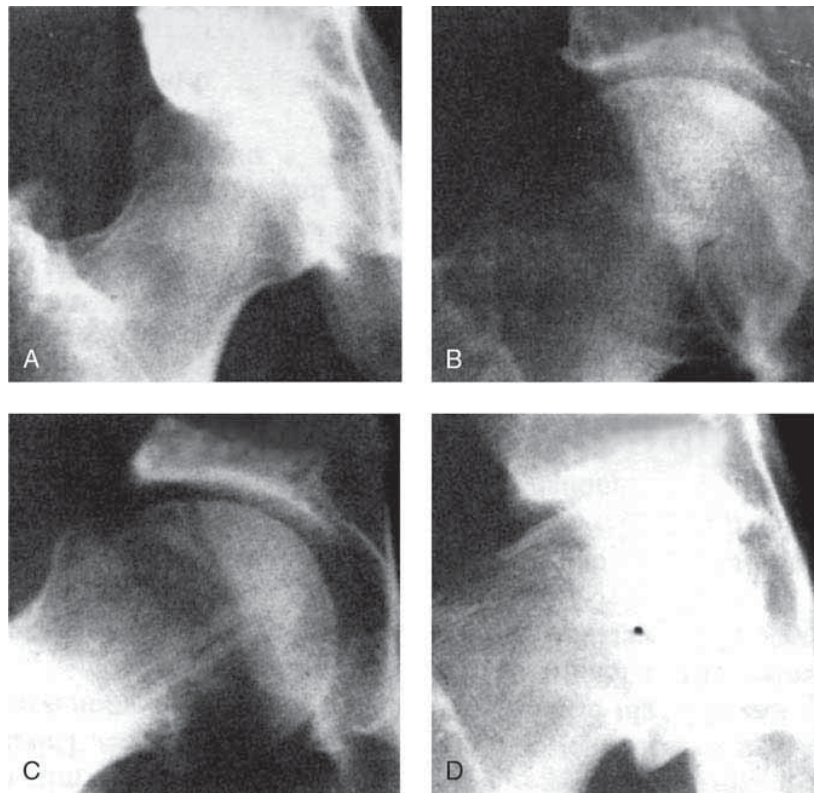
AP radiographs of a normal hip and three forms of abnormalities associated with mild slipped capital femoral epiphyses. A, Normal hip. B, Flattening. C, Bump. D, Hook. (Reproduced with permission from Stulberg SD, Cordell LD, Harris WH, Ramsey PL, MacEwen GD: Unrecognized childhood hip disease: A major cause of idiopathic osteoarthritis of the hip, in Amstutz HC (ed): *The Hip: Proceedings of the Third Open Scientific Meeting of the Hip Society*. St. Louis, MO, CV Mosby, 1975, pp 212-228.)
